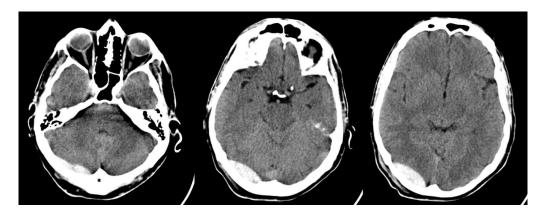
First computed tomography scan performed after the trauma. It shows the presence of a combined supra-subtentorial epidural hematoma.
